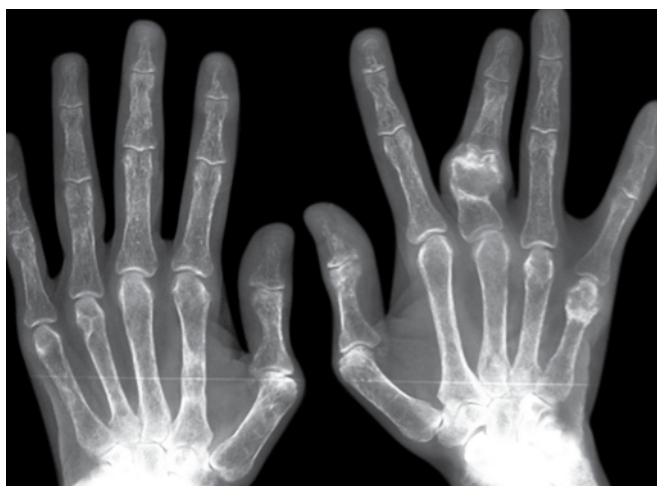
Radiograph of hand showing tuft resorption of distal phalanges, subperiosteal resorption and brown tumors
